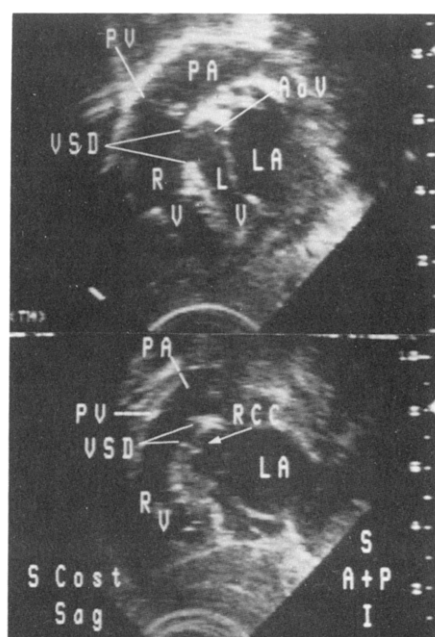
Two-dimensional echocardiographic display of a doubly committed subarterial ventricular septal defect (VSD) in two patients in a subcostal parasagittal view (SCost Sag). Top (Patient 11), The pulmonary valve (PV) and the aortic valve (AoV) lie at the same level above the large defect. Bottom (Patient 47), In a different patient this defect is covered almost completely by the right sinus of Valsalva. PA = pulmonary artery; other abbreviations as in Figure 3.
